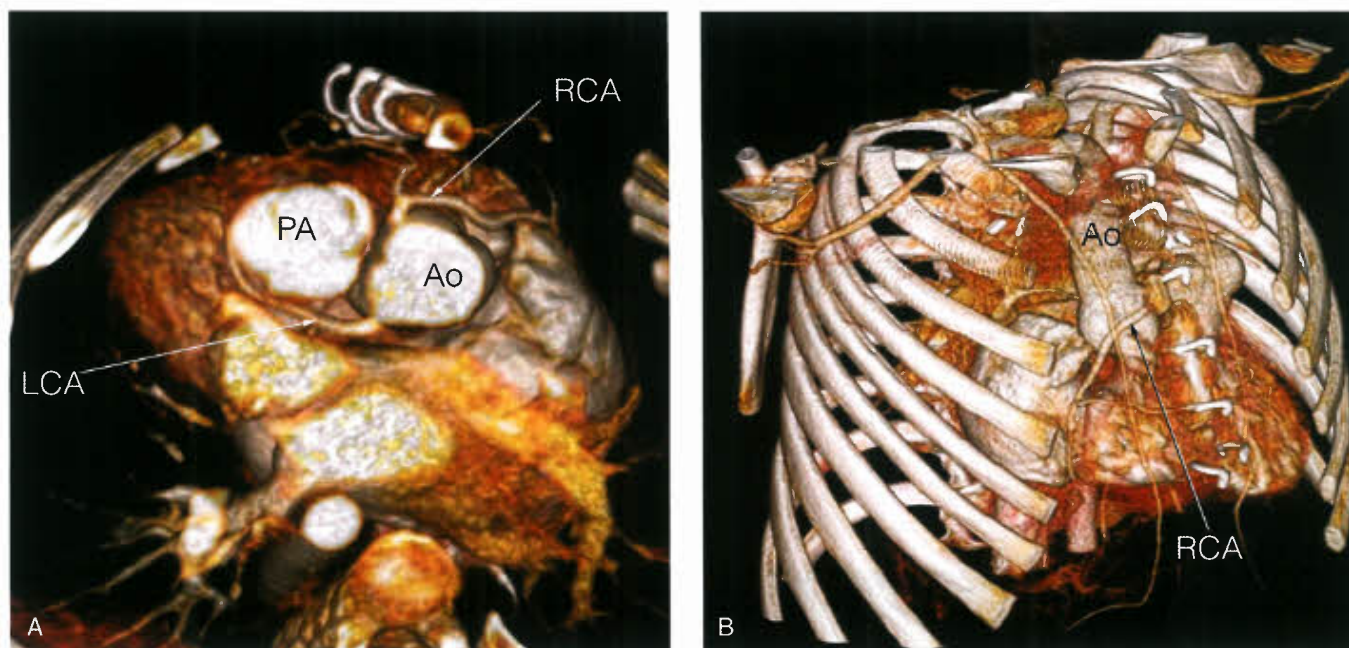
Coronary artery anomalies are of particular importance, because they may alter considerations for surgical repair due to their effect on feasibility of conduit placement or coronary transfer. CT angiograms demonstrate anomalous coronary origins and the relationship of the coronaries to the sternum well. A: CT angiogram, 3-D reconstruction: The right coronary artery (RCA) arises anteriorly and passes just under the sternum. LCA, left coronary artery; PA, pulmonary artery; Ao, aorta. B: CT angiogram, 3-D reconstruction: In a different patient, the RCA arises anomalously and crosses anterior to the aorta. Ao, aorta; RCA, right coronary artery.
